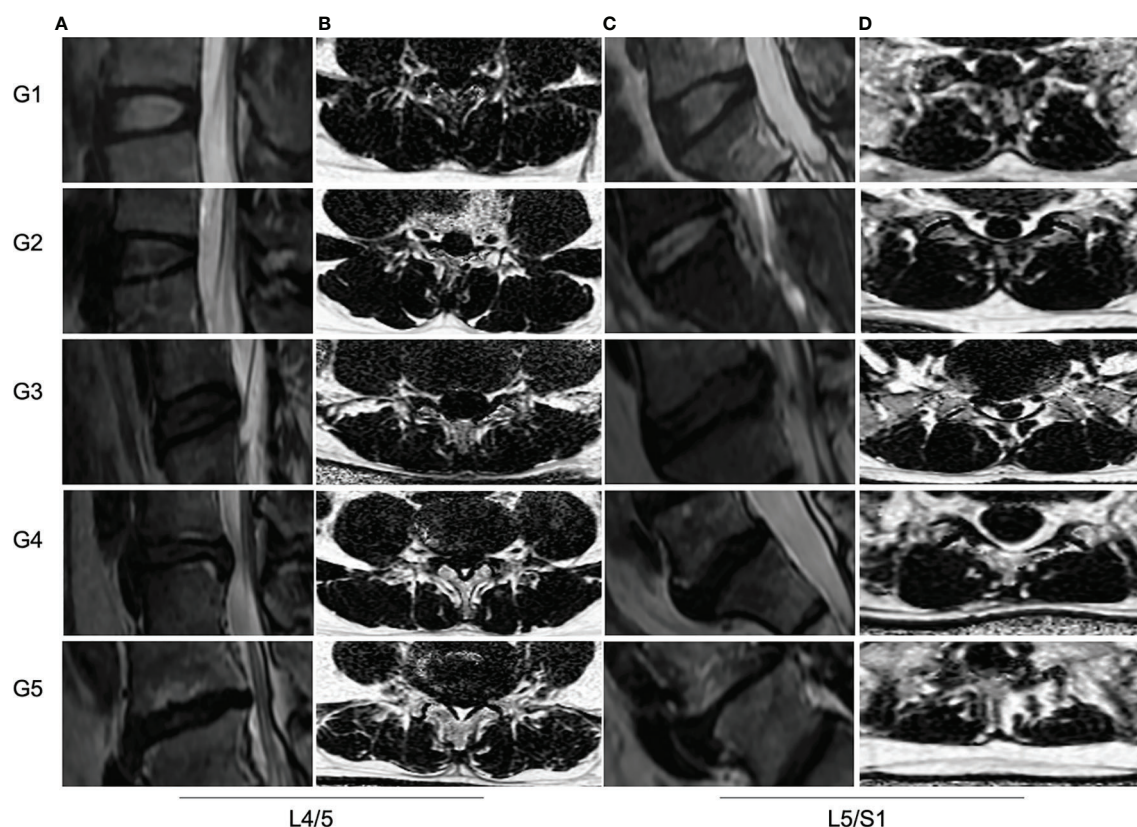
MRI PDFF of lumbar paraspinal muscles at different Pfirrmann grade of IVDs degeneration. (A, C) Sagittal T2 images of IVDs at L4/5 and L5/S1 levels. The Pfirrmann grade of IVDs degeneration from left to right are for G1, G2, G3, G4 and G5, respectively. (B, D) The PDFF of paraspinal muscles at L4/5 and L5/S1 levels. The mean PDFF at the L4/5 from up to bottom are for 9.1%, 10.5%, 14.2%, 16.3% and 22.3%, respectively. The mean PDFF at L5/S1 from up to bottom are for 10.8%, 12.1%, 14.0%, 16.5% and 24.0%, respectively.
